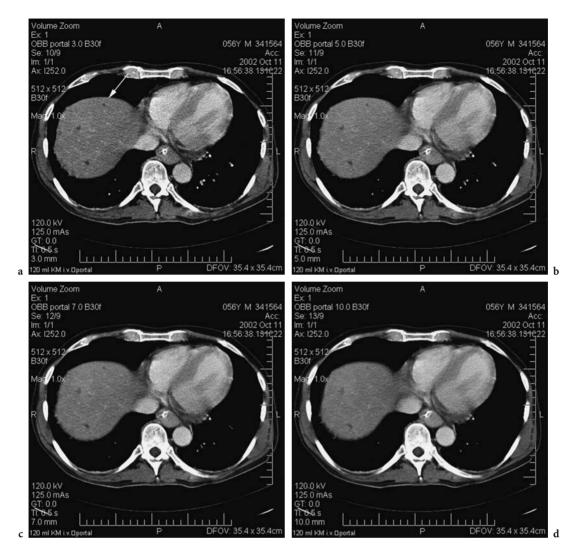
Multi-slice computed tomography (MSCT) examination of the liver performed on a MSCT scanner (Siemens Somatom Volume Zoom) at 120 kV, 4×2.5 mm slice collimation and 125 mAs_{eff} (CTDI_{vol}=11 mGy). From the same raw data set, slices of different thickness [3 mm (a), 5 mm (b), 7 mm (c), and 10 mm (d)] were reconstructed at the same central position z_0 . Despite the increased noise pertaining to thinner slices, the visibility of small lesions improves remarkably owing to reduced partial volume effects. This is clearly demonstrated by a lesion approximately 3 mm in size (*arrow*) (courtesy Dr. Wedegaertner, University Hospital Eppendorf, Hamburg, Germany)
